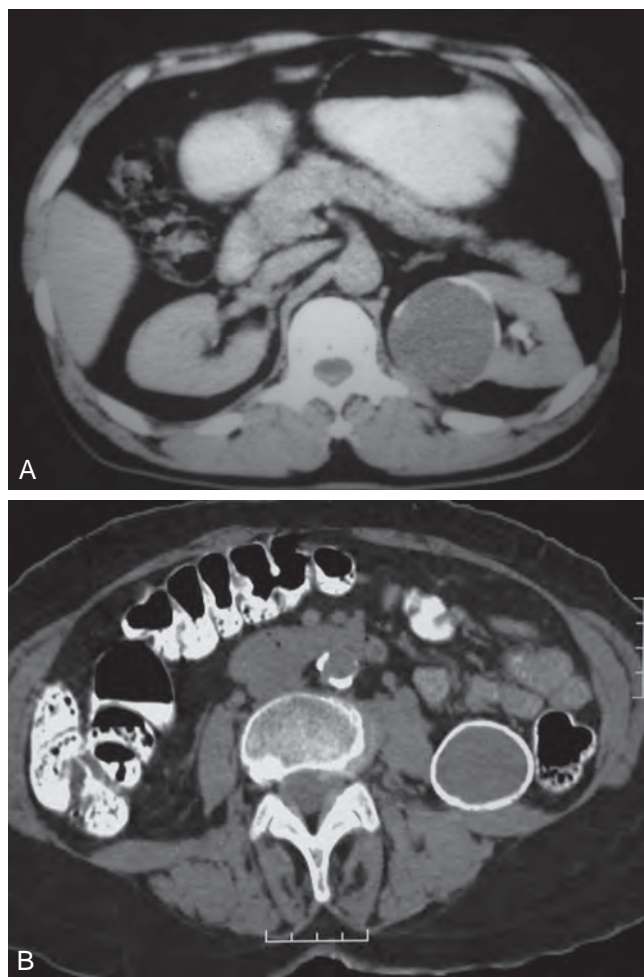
A and B, Two examples of Bosniak category II F cysts with diffuse calcification but no enhancement of septa on computed tomography. (Courtesy Jeffrey Newhouse, MD.)
